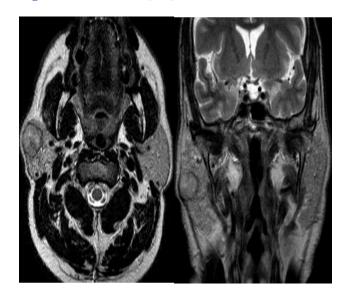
Parotid MRI, T2, axial and coronal sections.
